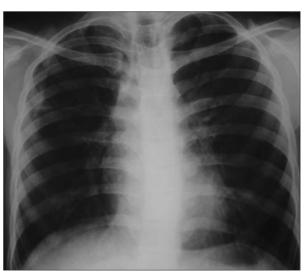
Chest radiograph which is grossly normal except bilateral increased reticular markings.
